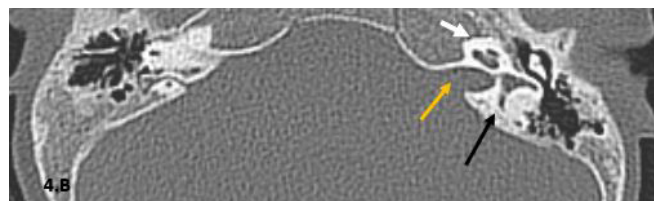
B: Axial CT view, bone window revealed normal vestibular morphology (black arrow), and average IAC diameter (yellow arrow).
